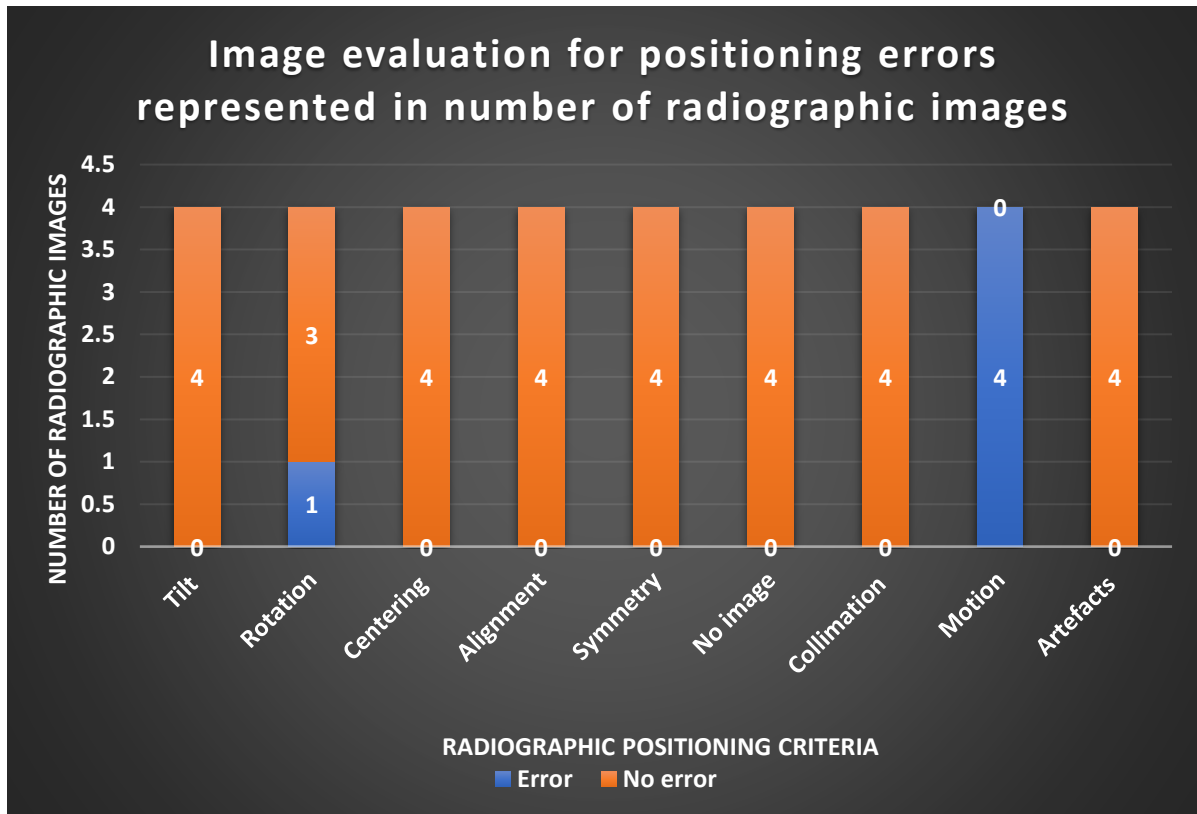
Number of errors versus no errors based on the seven radiographic image criteria (created by the researcher)
